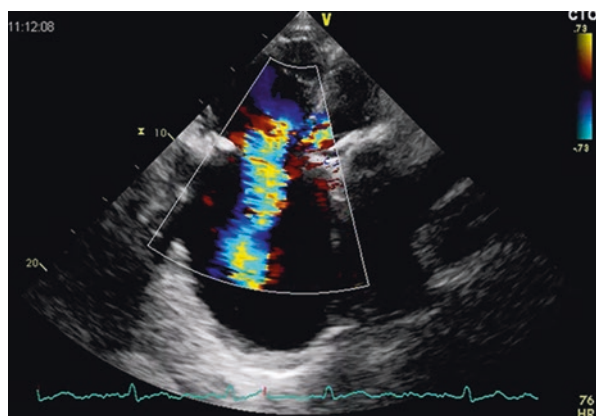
Echocardiographic image showing severe tricuspid regurgitation
